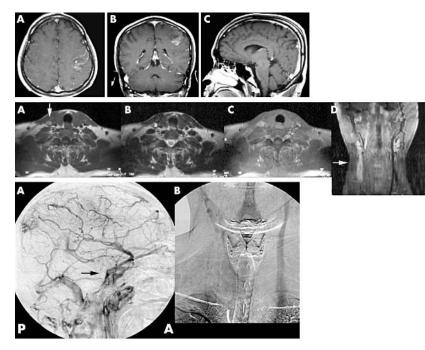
Top panel: post enhancement T1-weighted magnetic resonance (MR) image of the head (A) axial, (B) coronal, and (C) sagittal. (A) and (B) show the left parietal haemorrhagic infarct. The superior sagittal sinus and right transverse sinus show high intensity signal within the lumen instead of the normal "flow void", indicating thrombosis. Middle panel: MR image of the neck (A) T1-weighted, (B) T2-weighted, (C) post enhancement T1-weighted, and (D) coronal T2-weighted showing right internal jugular vein thrombosis without other structural abnormalities (arrows). Bottom panel: digital subtraction angiogram (A) lateral view of the head during the early venous phase of right carotid digital subtraction angiography confirms the non-opacification of the superior sagittal sinus, the deep cerebral venous system and the transverse sinuses. The predominant venous drainage is via the sphenoparietal sinus (arrow). (B) Anteroposterior view of the neck—the right jugular vein had an area of obstruction at its junction with the right subclavian vein.
